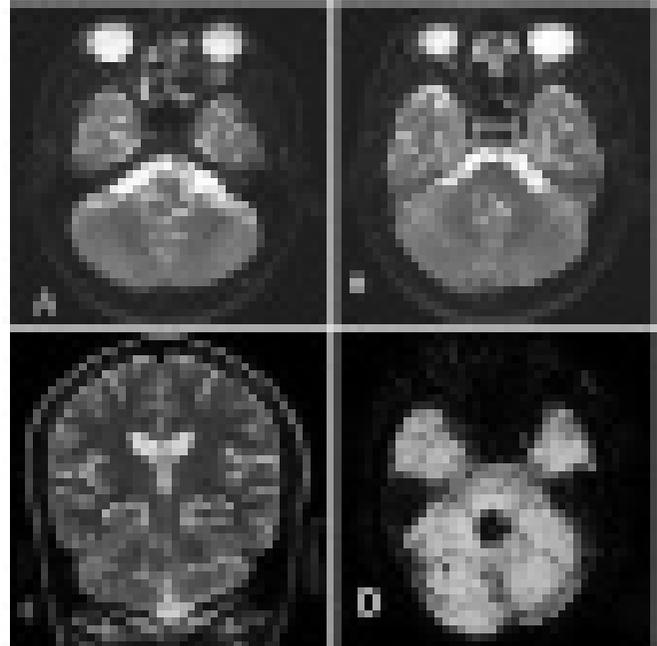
MRI Brain T2 Axial (A and B) and Coronal (C) Images Showing Isointense Lesion with Surrounding Area of Hyperintensity Inferomedial to the Right Middle Cerebellar Peduncle and Posterolateral to the Medulla. SWI (D) Image Shows Marked Blooming of the Lesion
